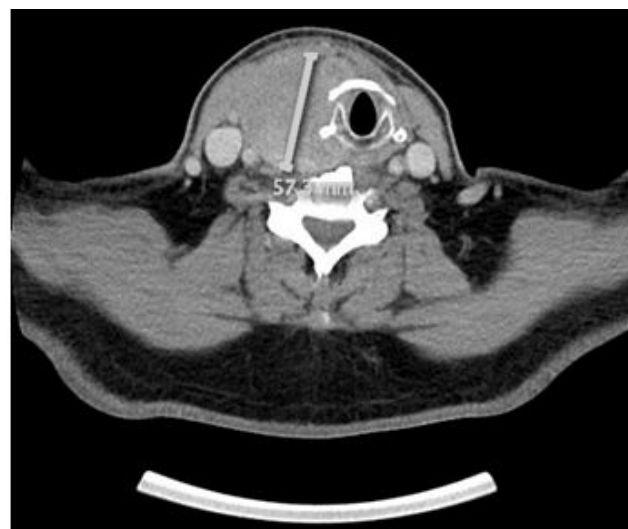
Pre-treatment CT scan showing the larger thyroid mass.
